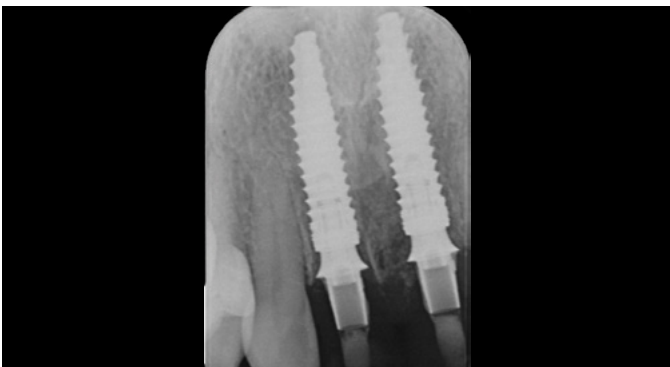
One-week post-operative radiograph
